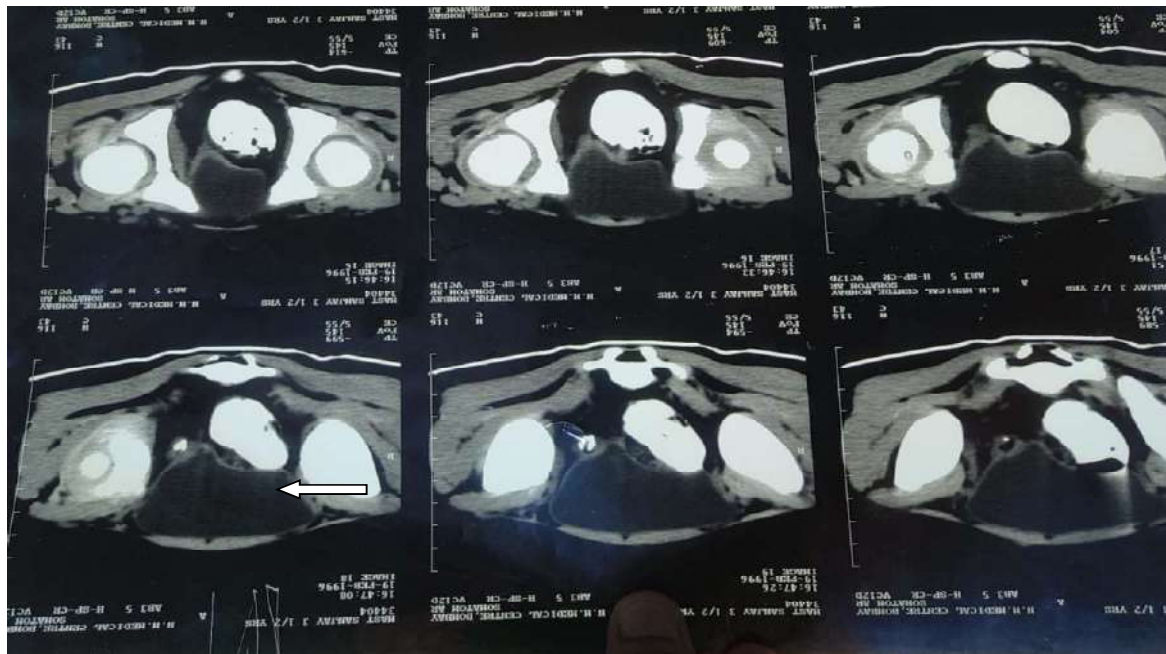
Serial axial sections of CT scan with oral contrast showing the fistulous communication of Colovesical fistula.
